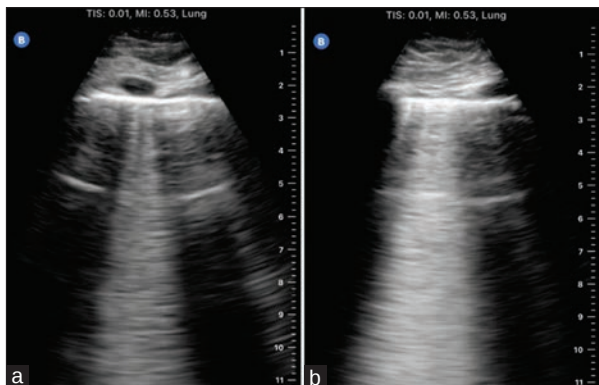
Point-of-care ultrasound lung ultrasound abnormalities in both lungs. (a) Regular pleural line and confluent B-lines in the right lung, (b) Regular pleural line and multiple B-lines in the left lung.
